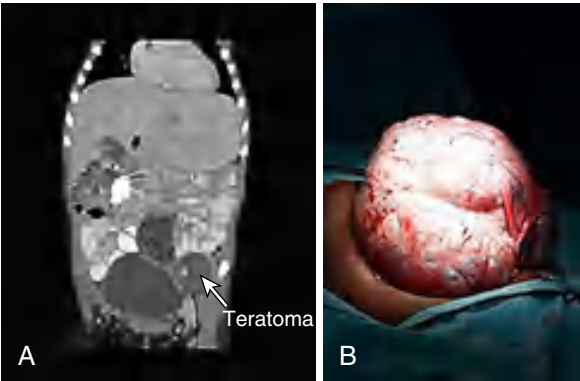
A, Postnatal MR image showing a left ovarian teratoma with bony calcification. B, Massive ovarian teratoma. (From Lakhoo K. Neonatal teratomas. *Early Hum Dev*. 2010;86:643–647.)
